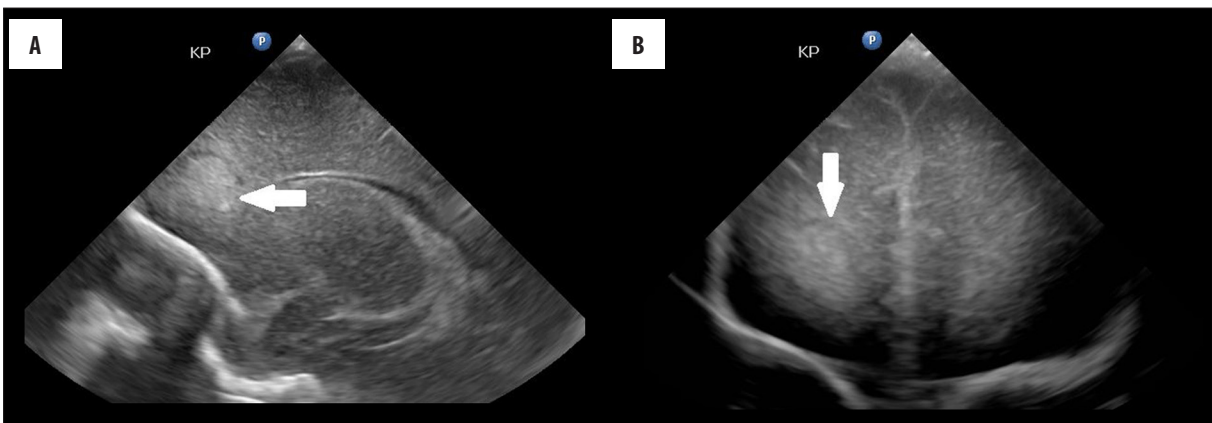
Cranial ultrasonography of the patient on the 40th day of life. (A) Frontal plane image showing a hyperechogenic change (abscess) located in the right frontal lobe (white arrow). (B) Sagittal plane image showing a hypoechogenic halo surrounding the abscess located in the right frontal lobe (white arrow).
